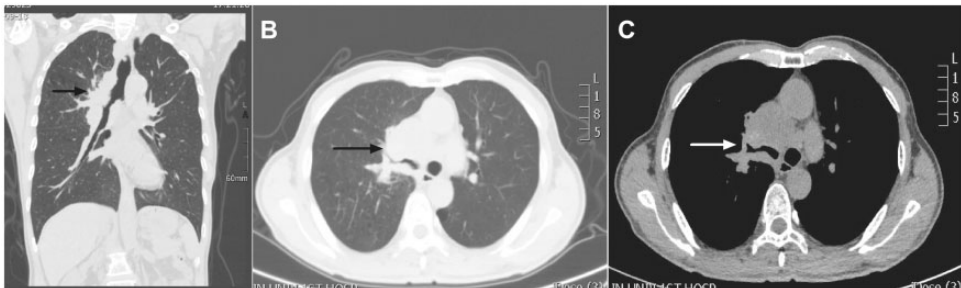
Coronal (a), lung window (b) and mediastinal window (c) computed tomography images of a 64-year-old man who presented with a painless mass below the right ear and complained of peripheral facial paralysis for a month. The images show abnormalities in the upper and middle lobes of the right lung and intermediate bronchus and obstructive pneumonia. Enlargement of the right hilar and mediastinal lymph nodes, indicated by black and white arrows, is also visible.
